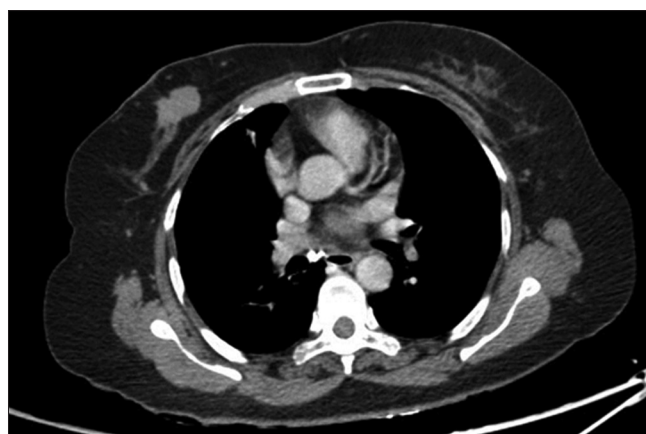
CT images show the right breast lesion
